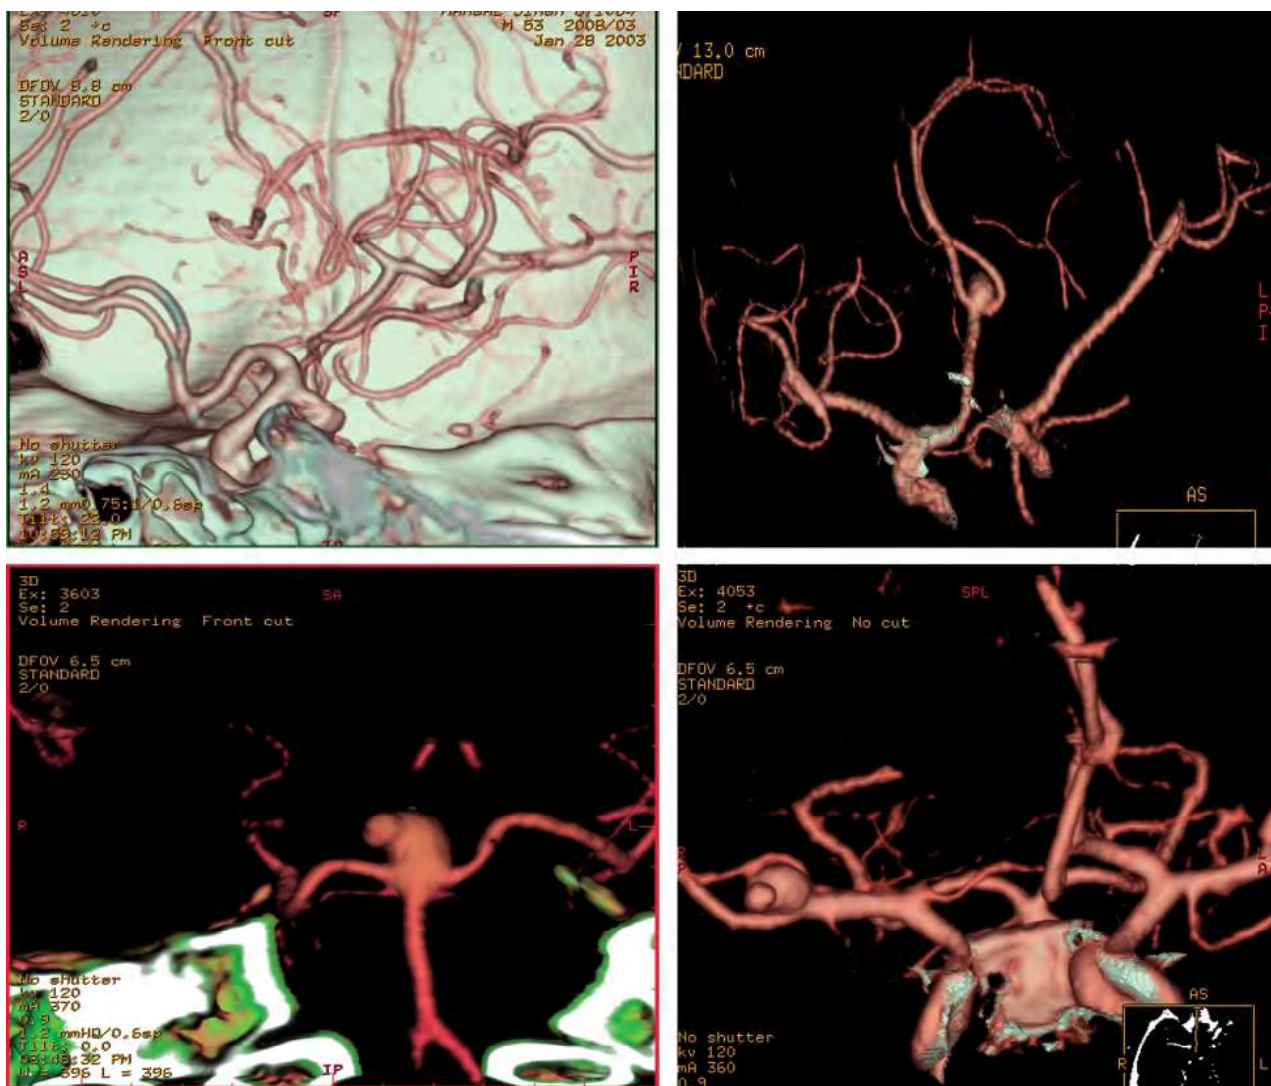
Computed tomography angiography—multiple aneurysms
